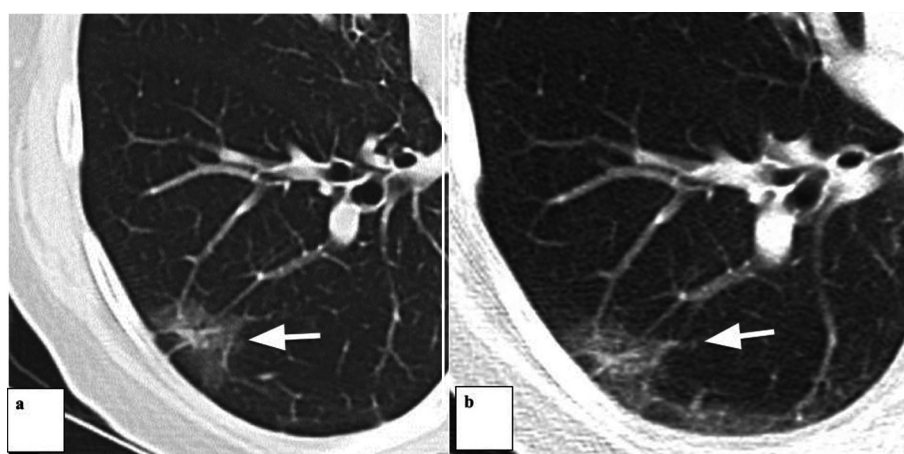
Chest CT in lung window and high resolution: subsolid nodule with central solid component, categorized as Lung-RADS 3 (arrows in a and b). Percutaneous biopsy under tomographic control, with AAH as a result. Performed after 6 months, determining lesion stability. Continues with periodic follow-ups.
